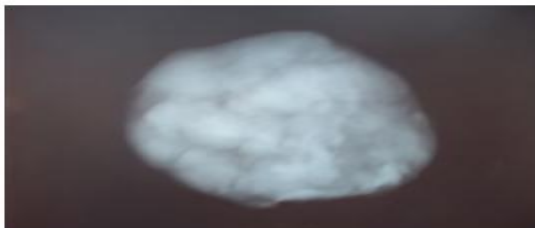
Radiograph of PIH placenta showing calcification
